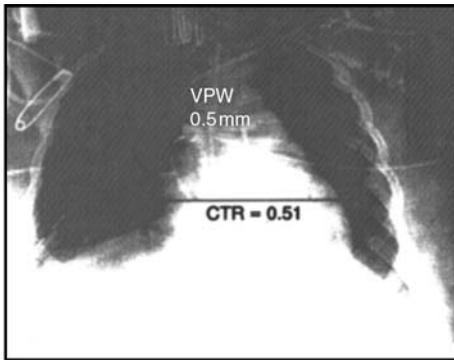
Representative portable, supine chest radiograph from a patient with acute lung injury. Vascular pedicle width (VPW) and cardiothoracic ratios (CTR) are depicted at presentation in the top figure. The bottom figure reveals a portable, supine chest radiograph from the same patient demonstrating a significant decrease in VPW and mild decline in CTR at day 5 after diuresis of 6.5 liters. *Abbreviations:* VPW, vascular pedicle width; CTR, cardiothoracic ratios. *Source:* From Ref. 80.
